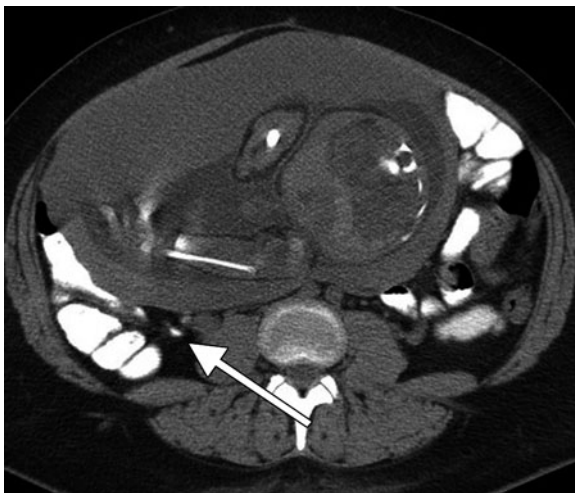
CT of 30-week pregnant patient with abdominal pain. Axial CT image with oral contrast shows a normal appendix filled with oral contrast (*white arrow*). The tube current was reduced by 30% for this acquisition
